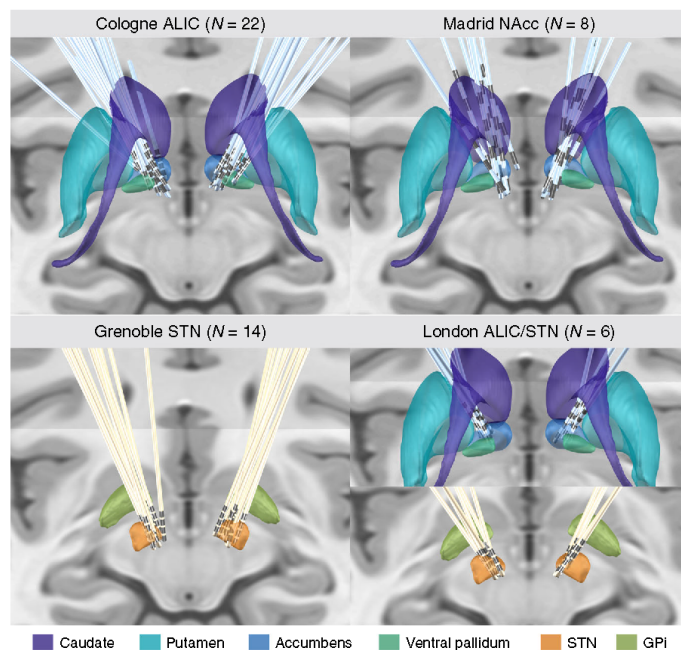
Overview of lead electrode placement. The two training/cross-validation cohorts (left) targeting ALIC (Cologne) and STN (Grenoble), and the two test cohorts (right) targeting NAcc (Madrid) and both ALIC & STN with four electrodes per patient (London) are shown. Subcortical structures defined by CIT-168 Reinforcement Learning Atlas⁶³ (ALIC/NAcc region) and DISTAL Atlas⁶⁴ (STN region), with coronal and axial planes of the T1-weighted ICMB 152 2009b nonlinear template as background.
